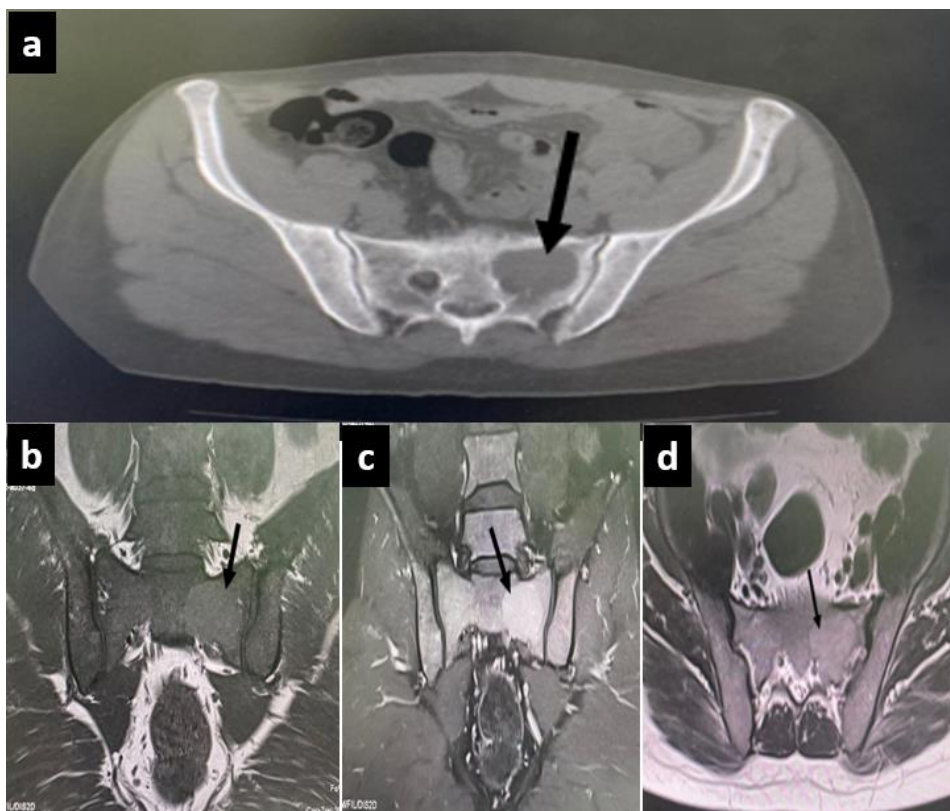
(a): Abdominopelvic CT scan showing a geographic lytic lesion in the left hemipelvis involving the first sacral foramen. (Arrow)
